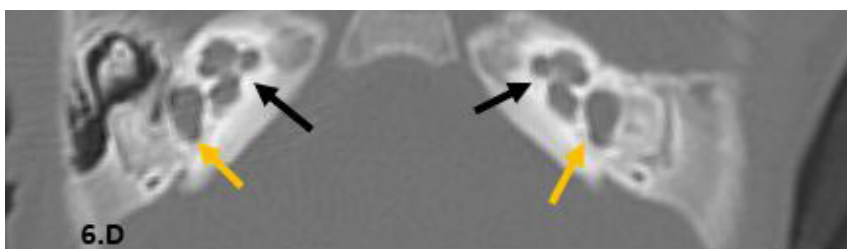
D: Axial CT view, bone window revealed normal bilateral cochlear morphology (black arrow), and both vestibules are within normal (yellow arrows).
